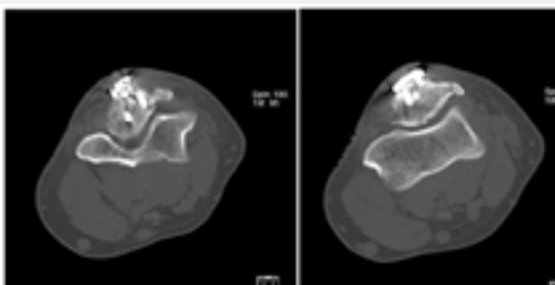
CT scan at 3y post op showing acceptable ulno-humeral congruency.
